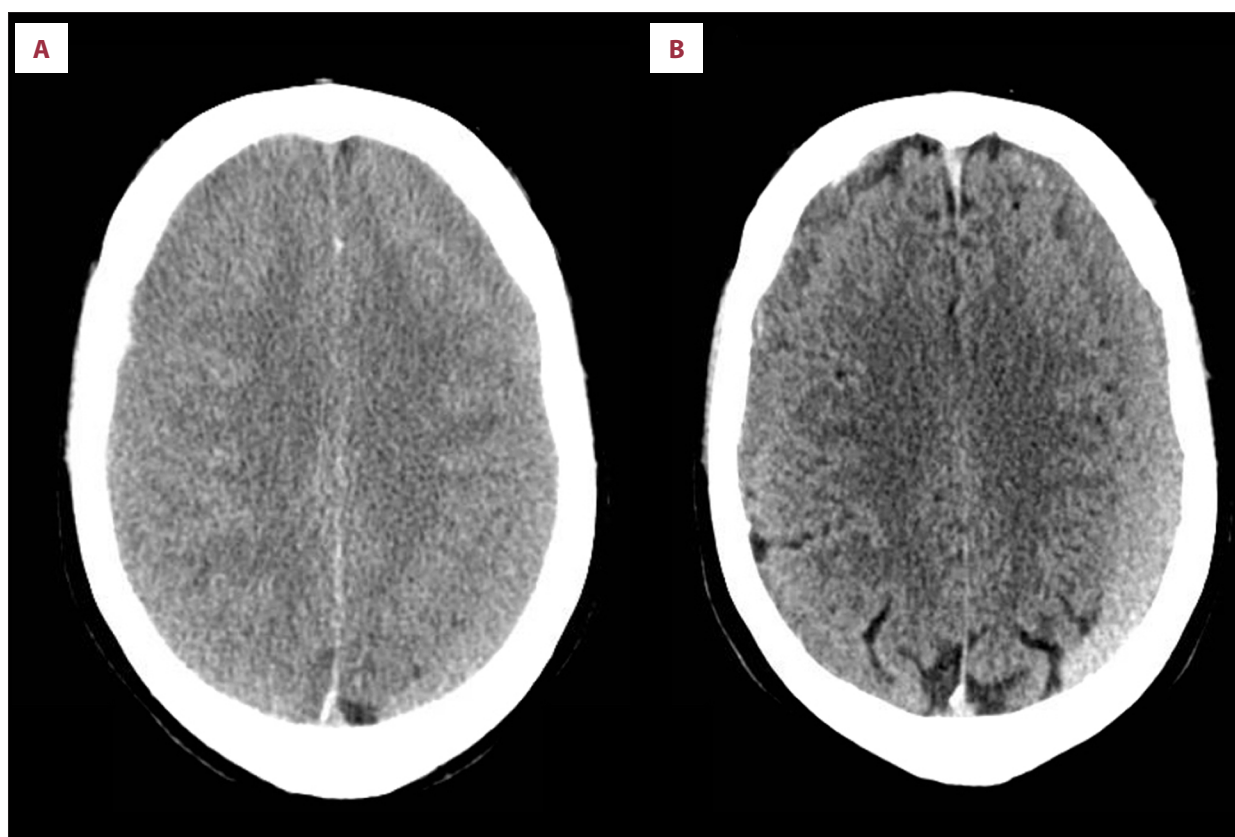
Computed tomography (CT) scan of bilateral chronic subdural hematoma (CSDH). (A) Computed tomography (CT) scan showing bilateral isodense chronic subdural hematoma (CSDH) with compression of the cerebral sulci. (B) CT scan six weeks after the first operation, showing reduced size of both hematomas, but with bilateral recurrence. The hematoma is compressing the left frontal lobe. The follow-up scans between this and the one prior to the fifth operation showed little difference.
